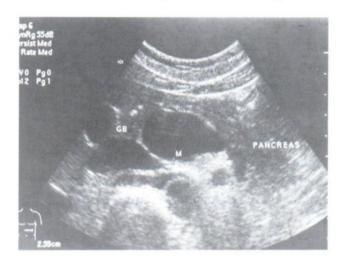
Transverse ultrasound scan of epigastrium reveals fusiform dilatation of the extrahepatic portal vein (M) measuring 4x3.5x2.6 cm. GB= gallbladder
